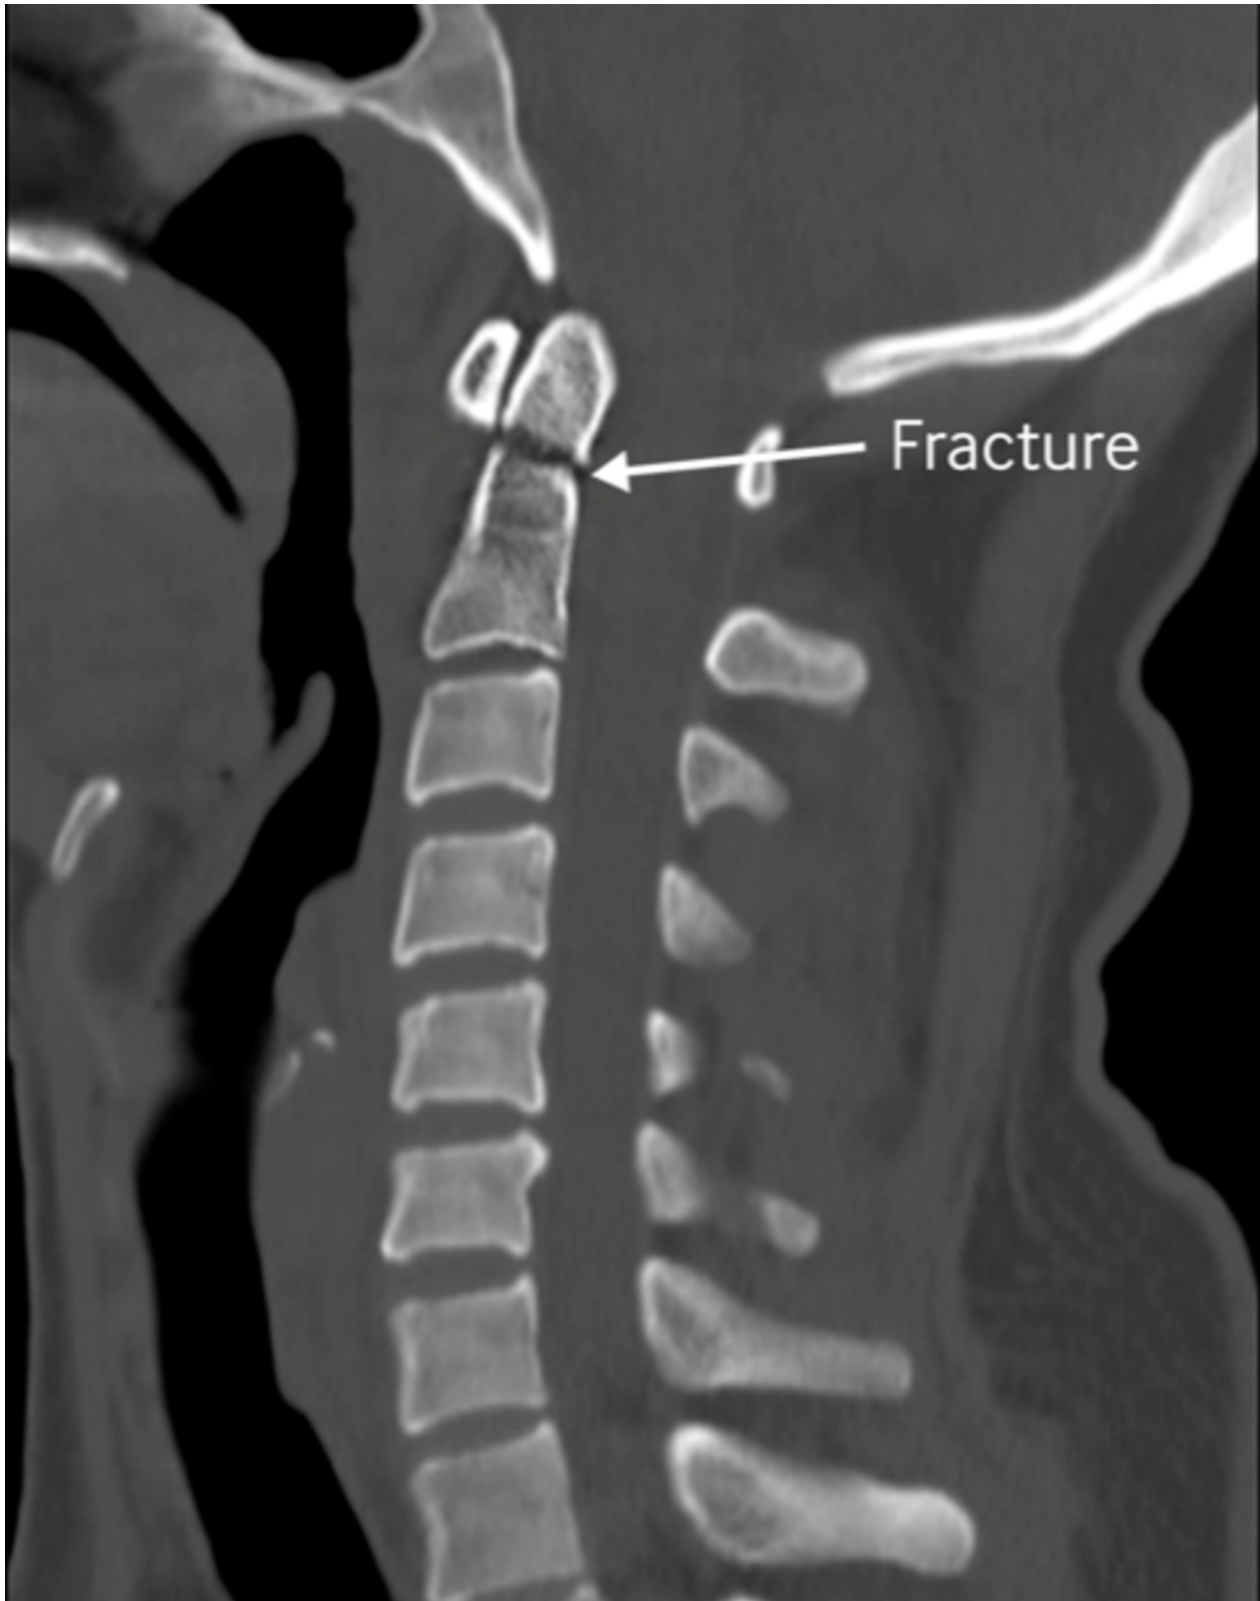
Sagittal computed tomogram (CT) showing a minimally displaced fracture of the second vertebrae and odontoid peg
